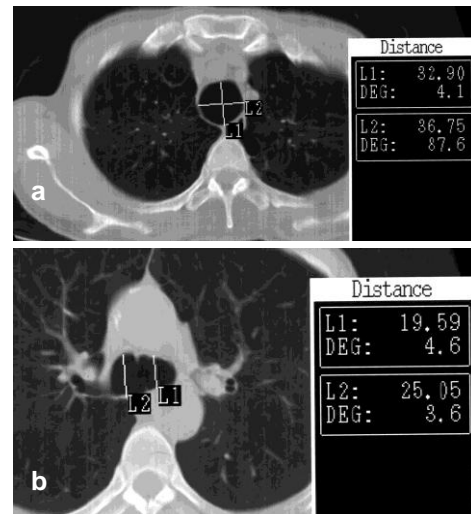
Second case's axial CT of the chest shows (a) increased diameters of trachea and (b) main bronchi.
